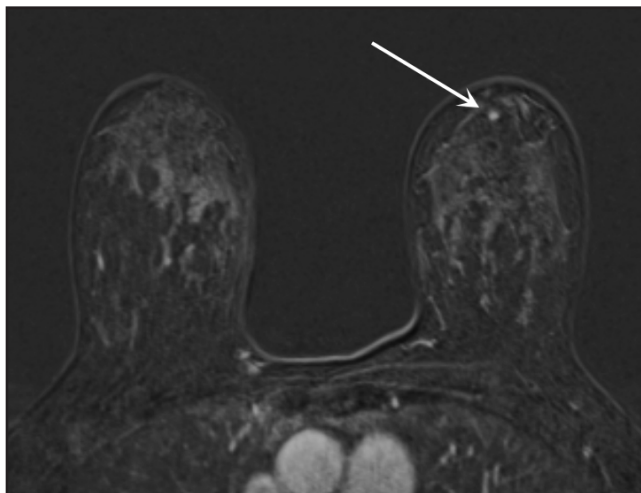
T1 fat-saturated postcontrast axial subtraction MRI (time-point 1) demonstrating an enhancing focus in the left breast at 11 o'clock anterior depth.
